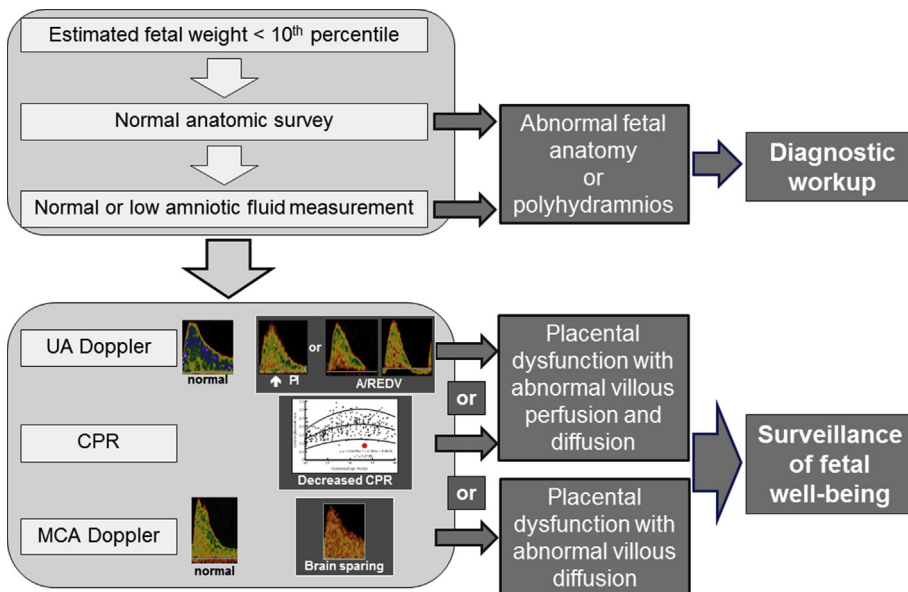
Diagnostic approach to identify the small fetus requiring surveillance. In a fetus with an estimated fetal weight below the 10th percentile, a detailed fetal anatomic survey should be performed. The presence of fetal anomalies or polyhydramnios is suggestive of other underlying mechanisms and should prompt appropriate diagnostic workup. In the anatomically normal fetus with normal or decreased amniotic fluid volume, an increased umbilical artery Doppler index, a decreased cerebroplacental Doppler ratio (CPR), or a decreased middle cerebral artery (MCA) Doppler index all suggest placental dysfunction. Small fetuses with any of these Doppler abnormalities are at risk for deterioration and require antenatal surveillance.
